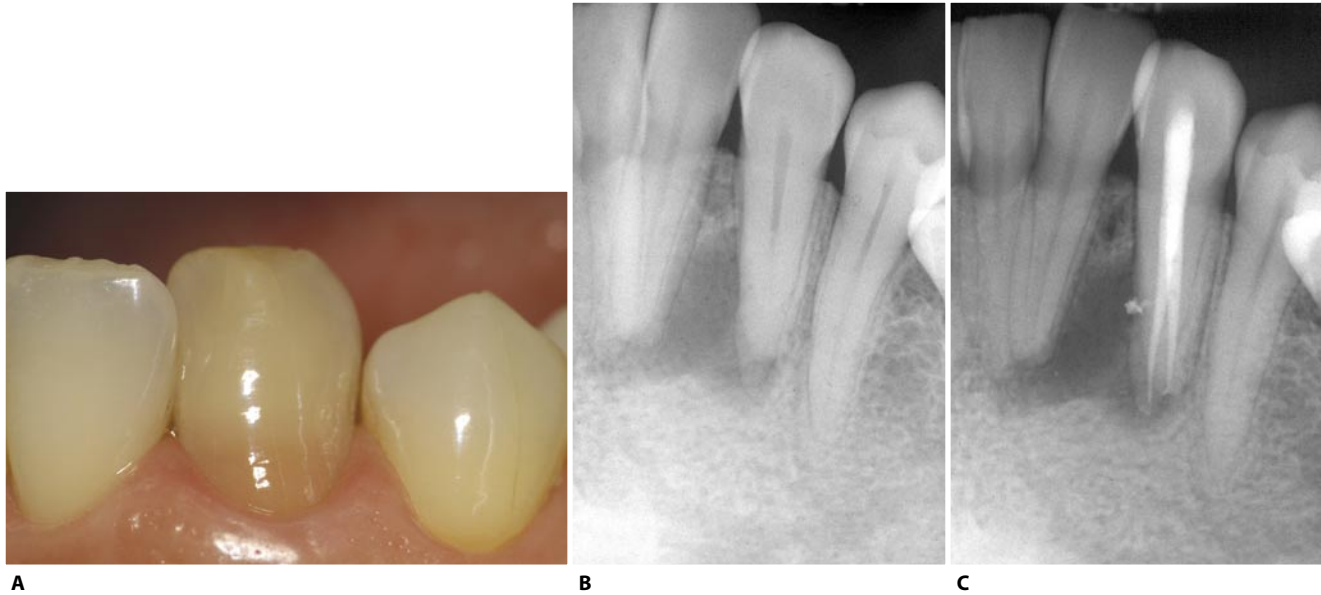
A, B. The chief complaint was the discoloration of the tooth. The radiograph shows a lesion involving the periapical and mesial areas of the cuspid and the distal aspect of the lateral incisor. C. Postoperative radiograph. The lateral incisor tests vital.
